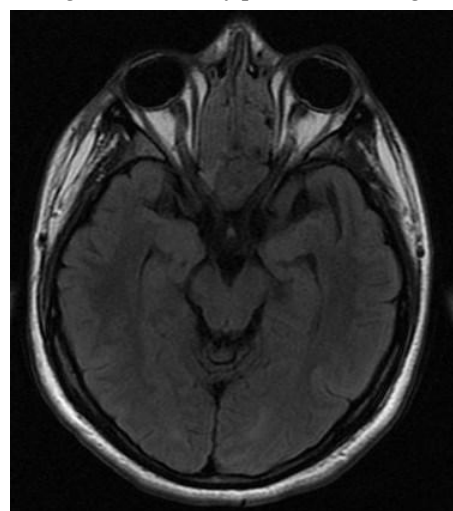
PRES - Axial view MRI FLAIR after 1 month showing resolution of previous changes
